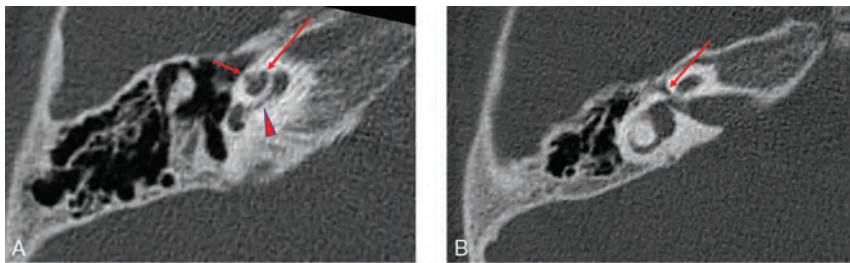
Temporal bone imaging appearance in a patient with *SIX1*-BOR. A, Axial CT image in bone algorithm shows absence of the cochlear offset; the middle turn (long arrow) is normally aligned relative to the basal turn (arrowhead) without anteromedial displacement. The thorny apical turn can also be appreciated (short arrow). B, Axial CT image in bone algorithm at a more superior level shows a normal course of the labyrinthine facial nerve canal (arrow) without medialization or widening.
